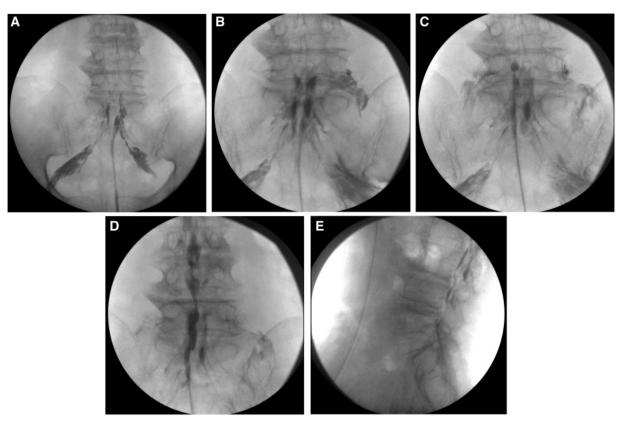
Representative epidurography for demonstrating complete contrast dispersion. Preprocedural epidurography (A) and postprocedural epidurography (B, C, D, and E) during combined balloon decompression and adhesiolysis. It presented filling defects above L5–S1 (A). Contrast medium was spread at the right and left foramina of L5–S1 (B, C). It also spread into the central, anterior, and posterior epidural space over L5–S1 after combined balloon decompression and adhesiolysis (D, E), and the filling defects on preprocedural epidurography were resolved. Contrast medium spread over all the target area as determined by location of pathology on lumbar magnetic resonance imaging, preprocedural epidurography, and clinical symptoms.
